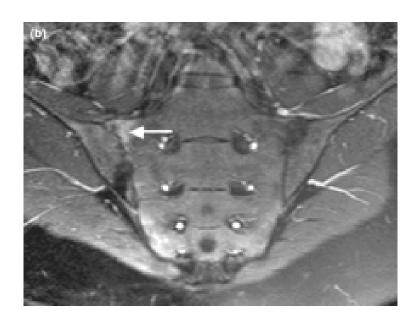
MRI Shows Right Side Sacroilitis
